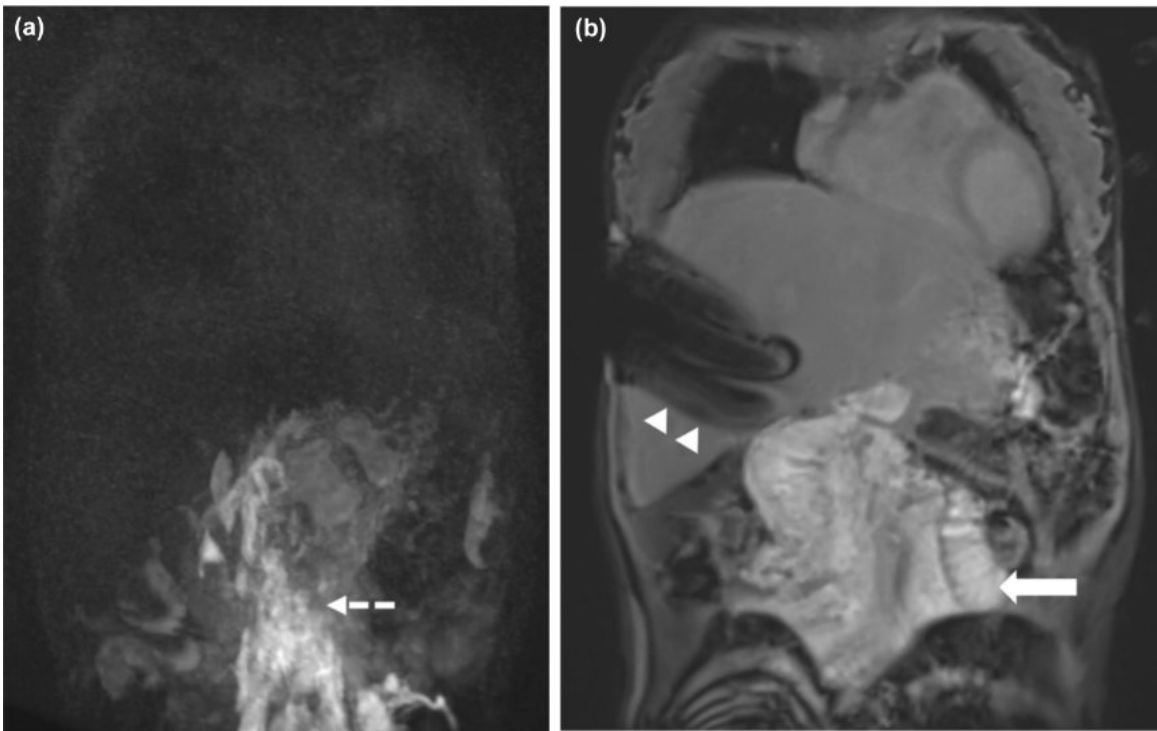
(a) Coronal maximum intensity projection time-resolved MR lymphangiography image acquired at 15 minutes post-contrast injection demonstrates abnormal retrograde mesenteric flow (dashed arrow) and absence of thoracic duct. (b) Coronal T1-weighted post contrast image acquired at 20 minutes shows contrast leakage into the small bowel (arrow), confirming chyle leak. Linear susceptibility artifacts from the intrahepatic needle was indicated by arrowheads.
